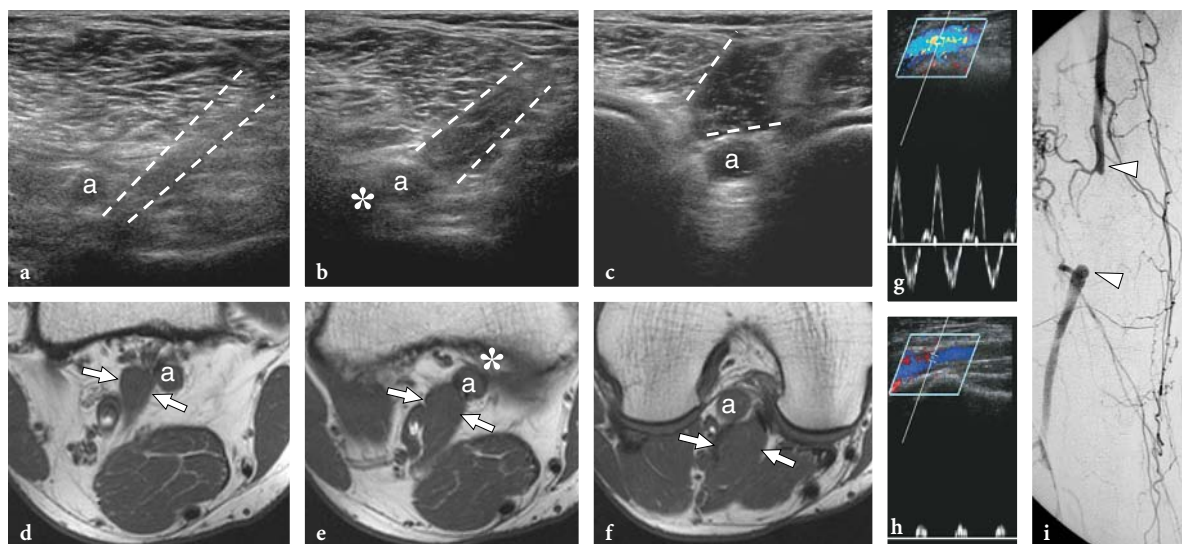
Popliteal artery entrapment syndrome. a–c Series of transverse 17–5 MHz US images of the popliteal fossa with d–f T1-weighted MR imaging correlation in a 45-year-old man with exercise-induced claudication of his right lower extremity demonstrate an anomalous medial course of the popliteal artery (*a*), which passes from medial to lateral across an abnormal muscle band (*dashed line* in a–c, *arrows* in d–f) lying in the popliteal fossa. At color Doppler imaging (not shown), the vessel occlusion initiated at the point where the artery is closely apposed to the posteromedial corner of the medial femoral condyle (*asterisk*) and is, therefore, vulnerable to compression by the anomalous muscle. MR imaging allowed this muscle abnormality to be classified as type 2. g,h Spectral Doppler analysis performed g at the upper-popliteal artery level and h downstream in the tibial artery at the proximal leg reveals g normal pulsatile flow cranial to the occlusion and h dampening of the distal flow waveforms. i Anteroposterior digital subtraction angiography shows segmental occlusion (*arrowheads*) of the popliteal artery with collateral filling through the geniculate arteries
